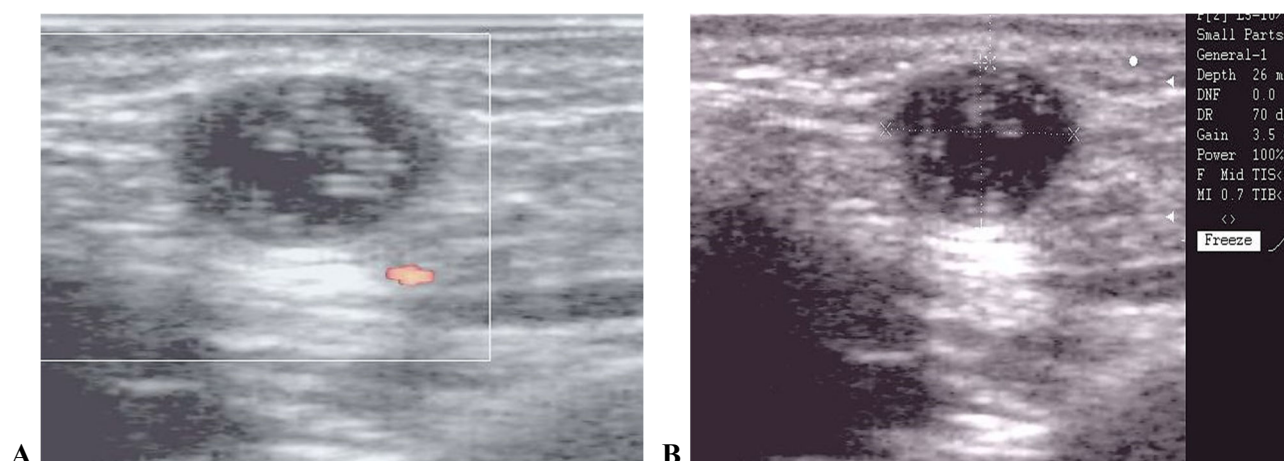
Ultrasound picture of the formation containing an intratissular parasite.
